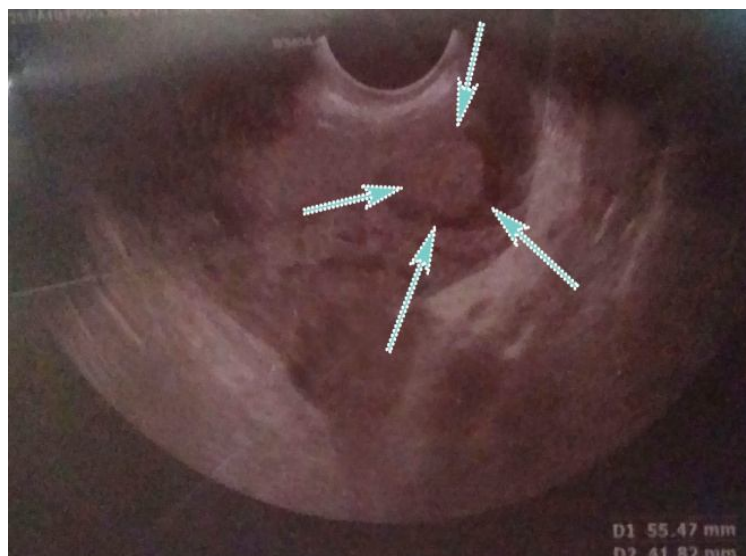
Ultrasound image of the abdomen shows heterogeneous area compatible with tubo-ovarian abscess (arrows)
